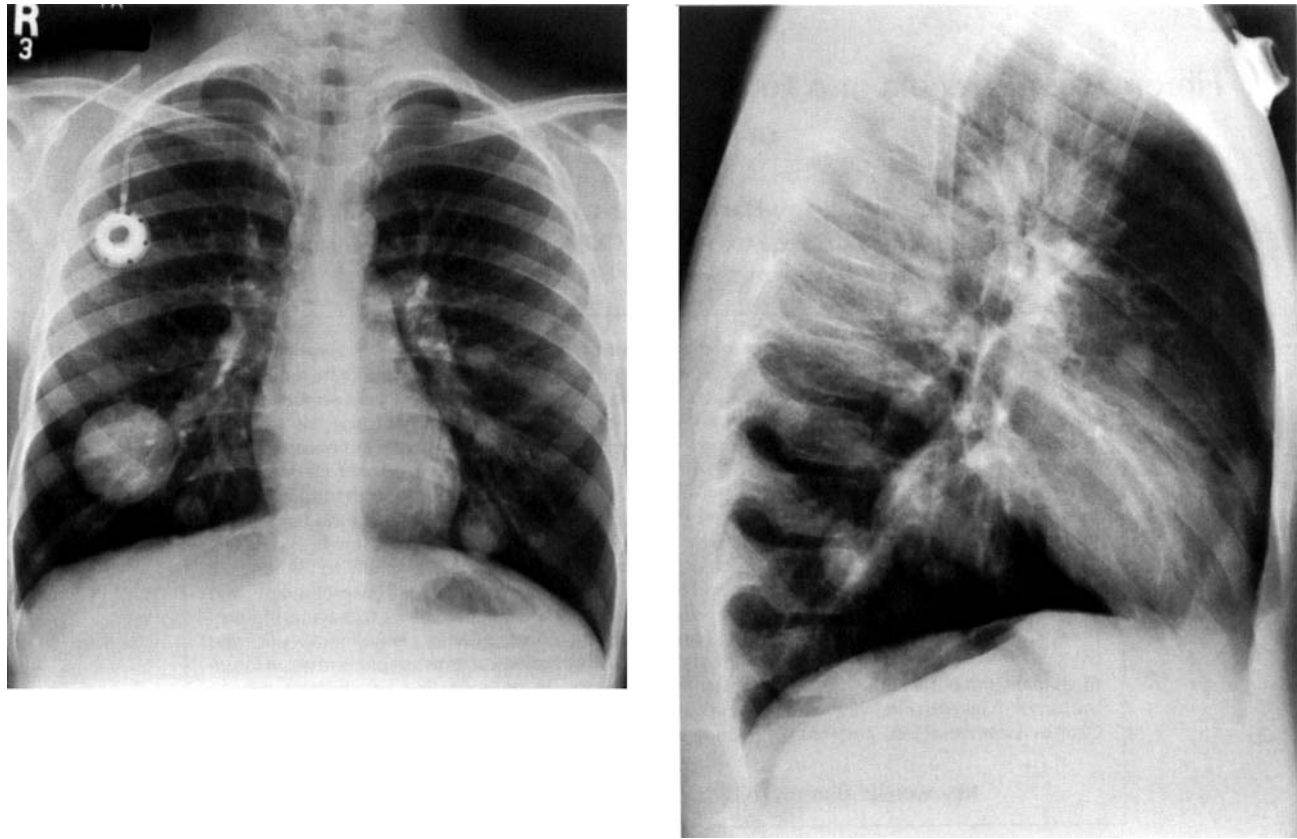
Posteroanterior and lateral radiographs of the chest display multiple bilateral lung metastases at the time of referral in August, 1993.
